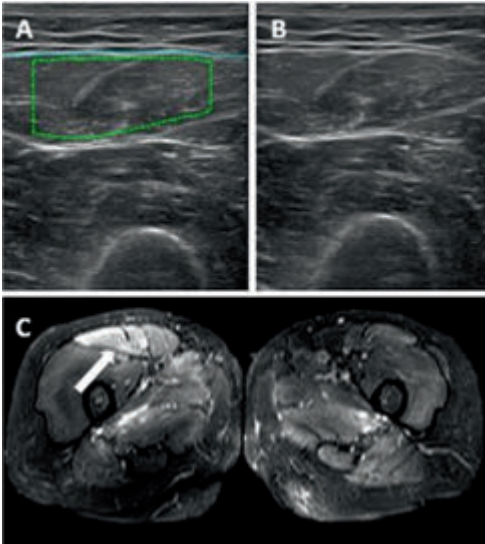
Images of the right rectus femoris of the same patient using different imaging modalities. Scoring for right rectus femoris muscle showed in figure: Panel A, quantitative US z-score 0.44; Panel B, qualitative US visually abnormal, Heckmatt score 2; Panel C, MRI score 2 (white arrow).
